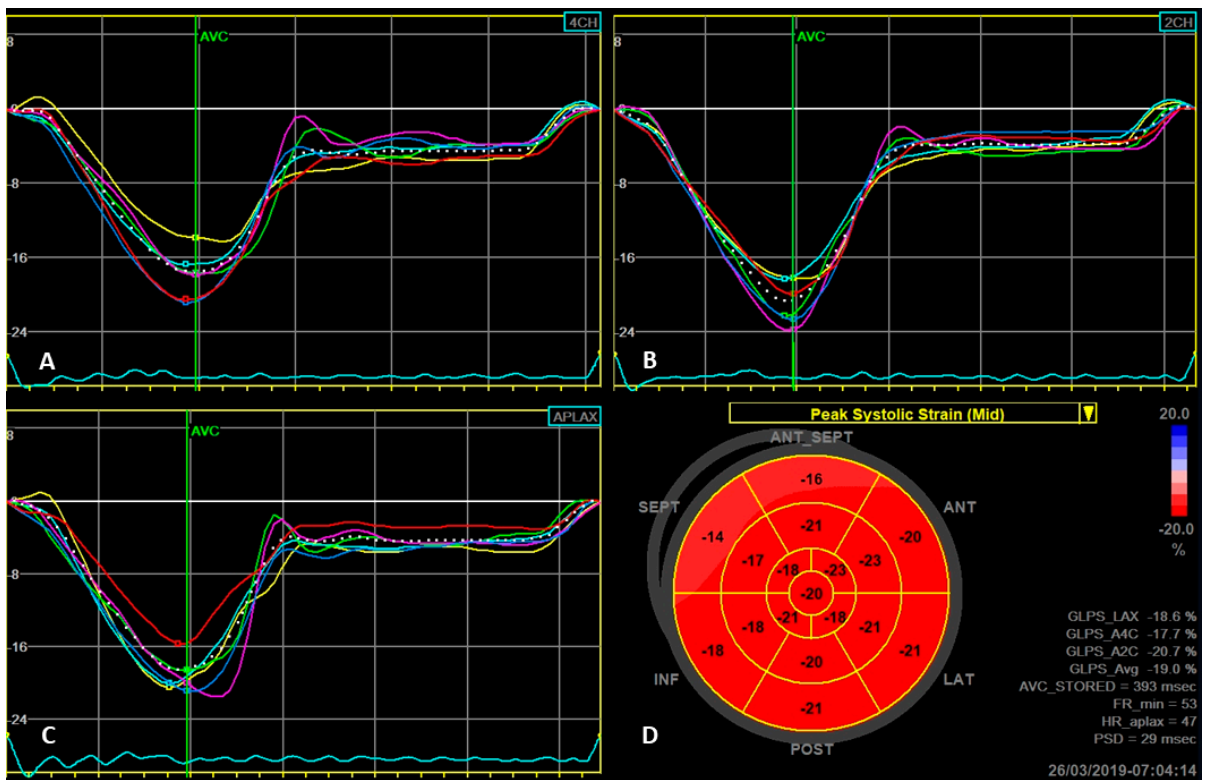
Normal values of longitudinal strain. Panels A, B and C show strain curves for left ventricular segments in apical four chamber-, two chamber and three chamber view, respectively. Dotted with line shows average value. Panel D – planar map of the peak systolic strain values for 17 segments of the left ventricle. Global longitudinal strain is – 19%.
